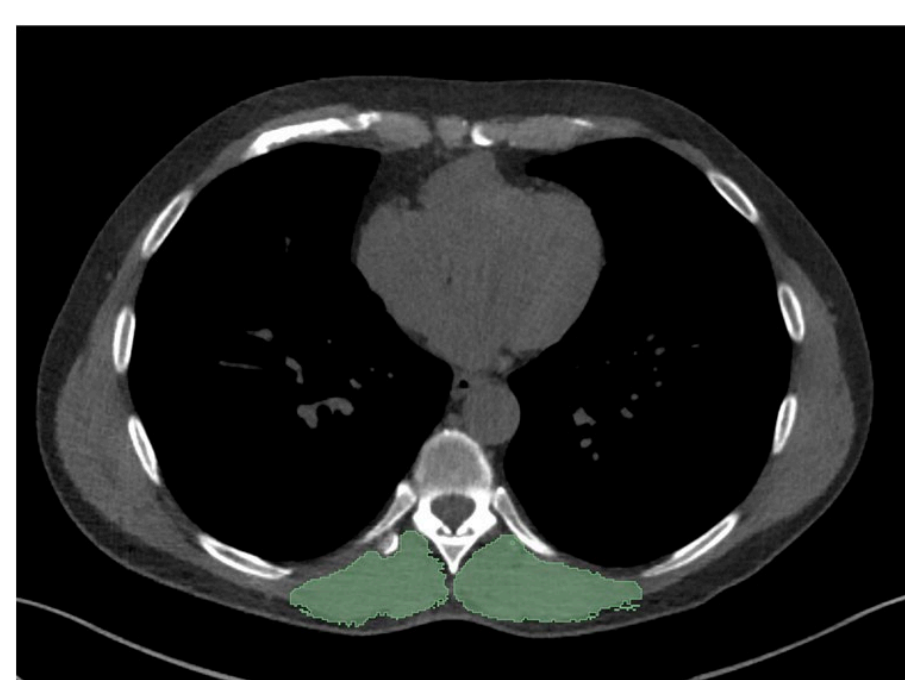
Paraspinal Muscle on Non-Contrast CT Scan, in green
